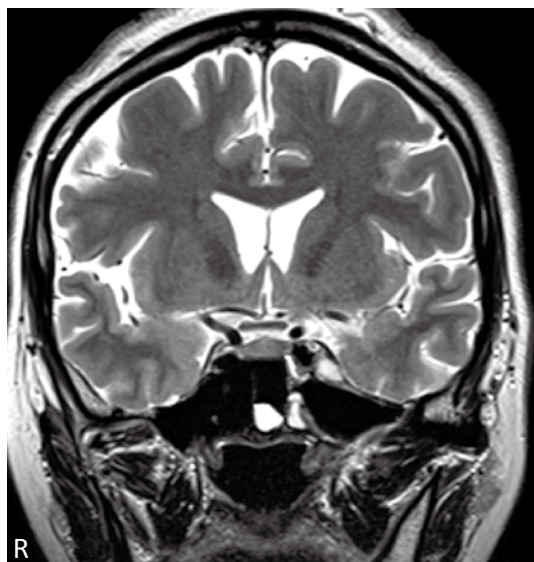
A coronal T2-weighted magnetic resonance image obtained a month after the operation confirmed the considerable size reduction of the cyst.
